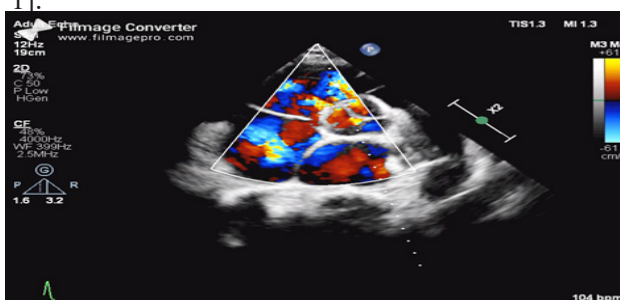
Echocardiogram of RSOV from right sinus
